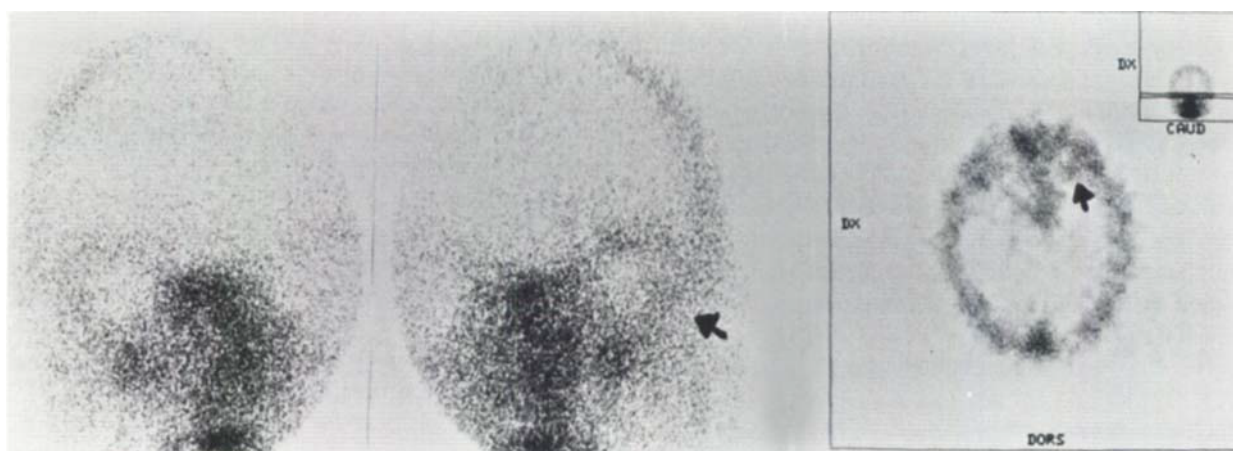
Uptake of ^{99m}Tc -labeled antibody in choroidal melanoma in left eye of a female patient aged 65 at 4–6 h postinjection. Gamma camera imaging in anterior projections (left and middle panels) was performed with a pinhole collimator and for SPECT (right panel) a parallel hole collimator was used.
